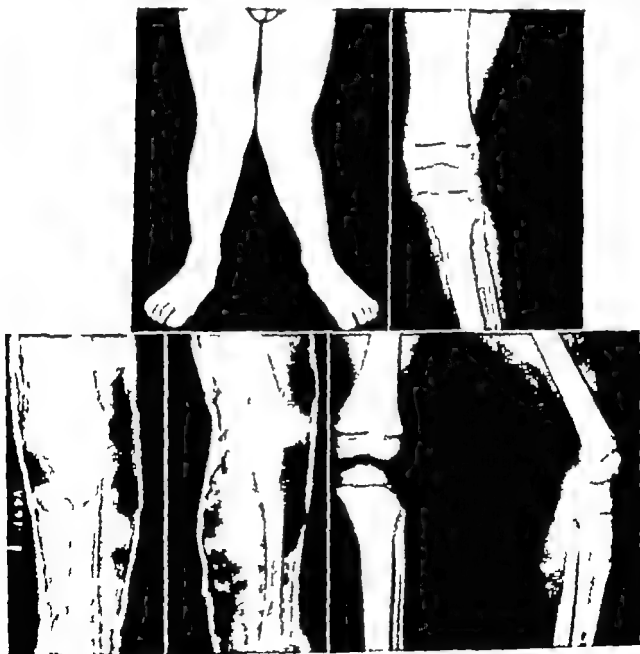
(Top left) Bilateral genu valgum in a child of 4. (Top right) Observe that the deformity is in the upper end of the left tibia. The roentgenograms clearly localize the lesion in the left extremity. (Bottom left) Correction of the left leg was achieved by an open wedge osteotomy on the lateral aspect of the upper end of the tibia. (Bottom right) Full correction still maintained 3 years later.
